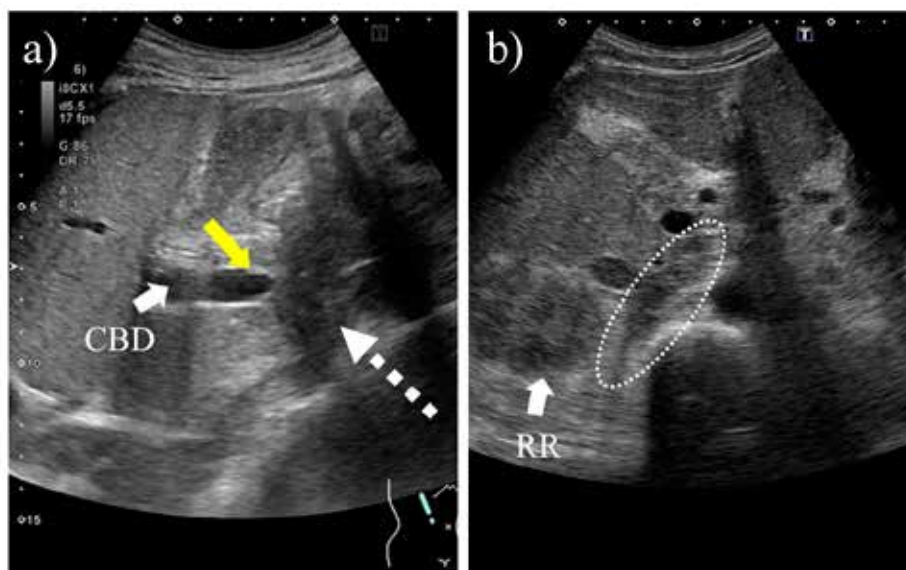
Abdominal ultrasonography. a: CBD is slightly dilated at 10 mm. The bile duct wall is thickened (yellow arrow). A hypoechoic area is seen around the portal vein (white dashed arrow). b: A 51 \times 14 mm hypoechoic area is lumped with the adrenal gland (dashed circle). CBD: common bile duct, RR: right renal
